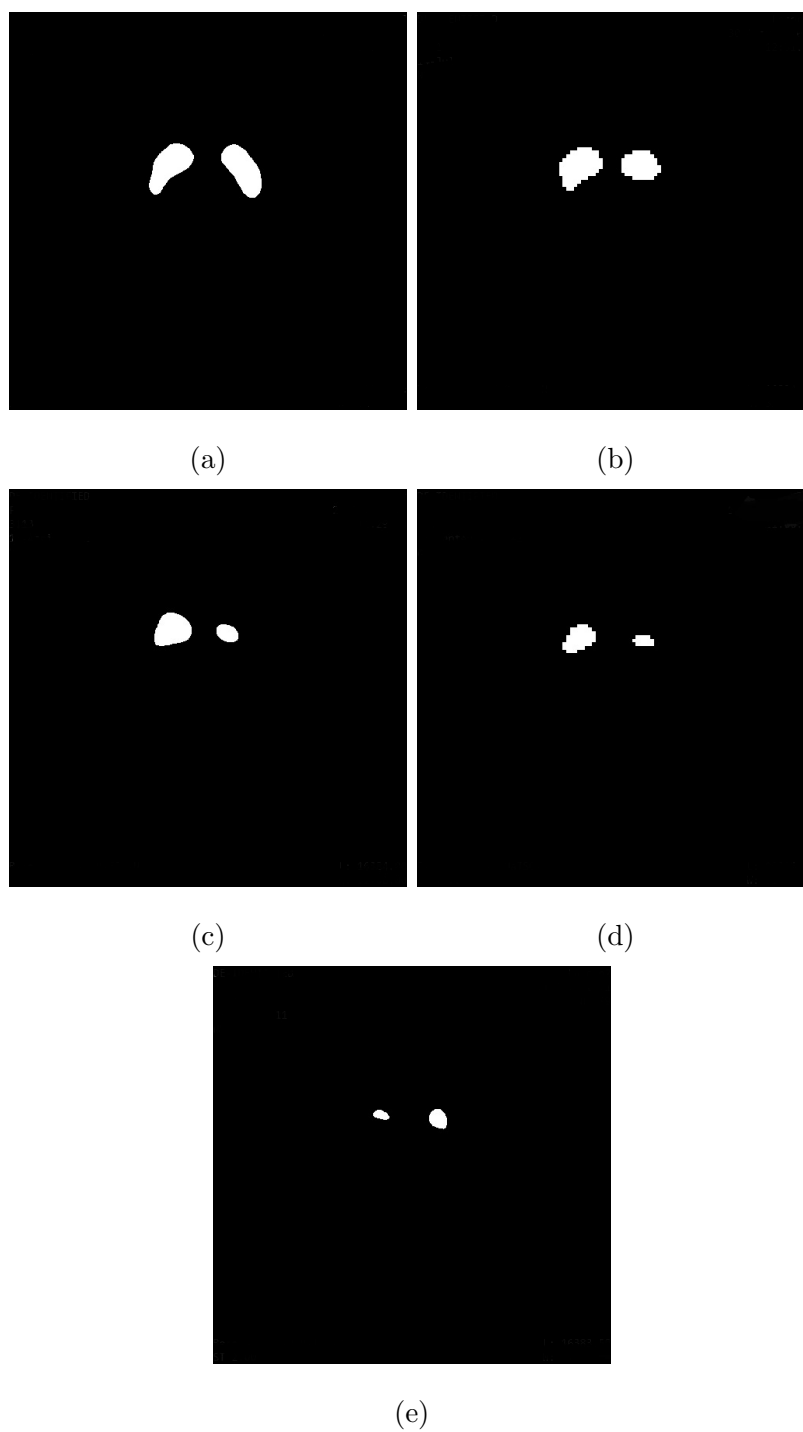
Segmented SPECT images of PD in (a) Stage 1, (b) Stage 2, (c) Stage 3, (d) Stage 4, and (e) Stage 5
